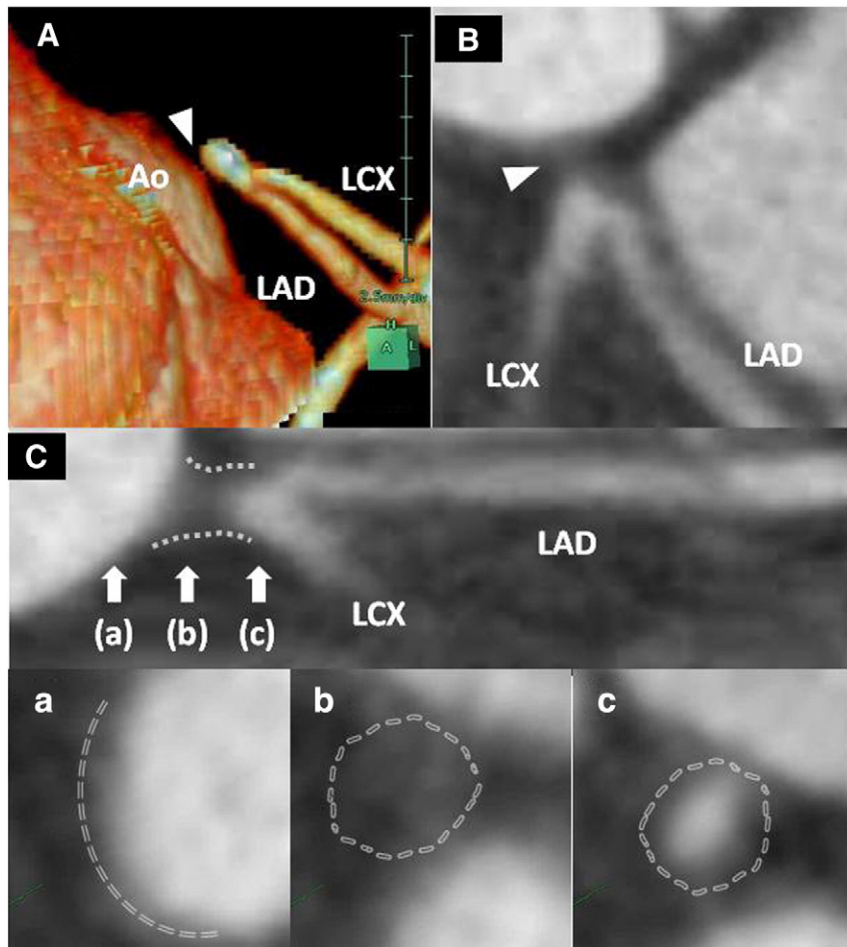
Coronary computed tomography angiography. (A) Volume rendering image and (B) curved multiplanar reconstructed image of the left coronary artery show an occlusion of the ostium in the left main coronary artery (arrow heads). (C) Stretched multiplanar reconstruction image of the left coronary artery depicts the occluded left main ostium (dotted line). The occluded segment contains a non-calcified component. (a) Cross-sectional image of the aorta. (b) Cross-sectional image of the occluded left main ostium; the occluded segment contains a non-calcified component. (c) Cross-sectional image of the distal left main coronary artery. Insets (a)–(c): The outer vessel area is traced with dotted line. Ao: Aorta; LAD: left anterior descending artery; LCX: left circumflex artery.
